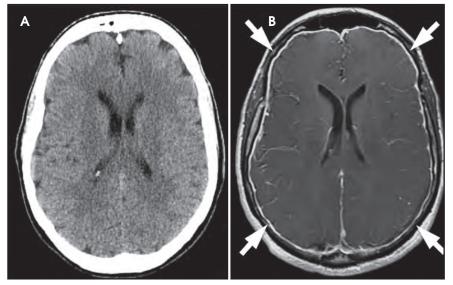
58-year-old man who developed a severe postural headache while lifting furniture. (A) Unenhanced axial CT image is normal. (B) Postcontrast axial T1-weighted image demonstrates diffuse, smooth dural enhancement (arrows) characteristic of intracranial hypotension.
